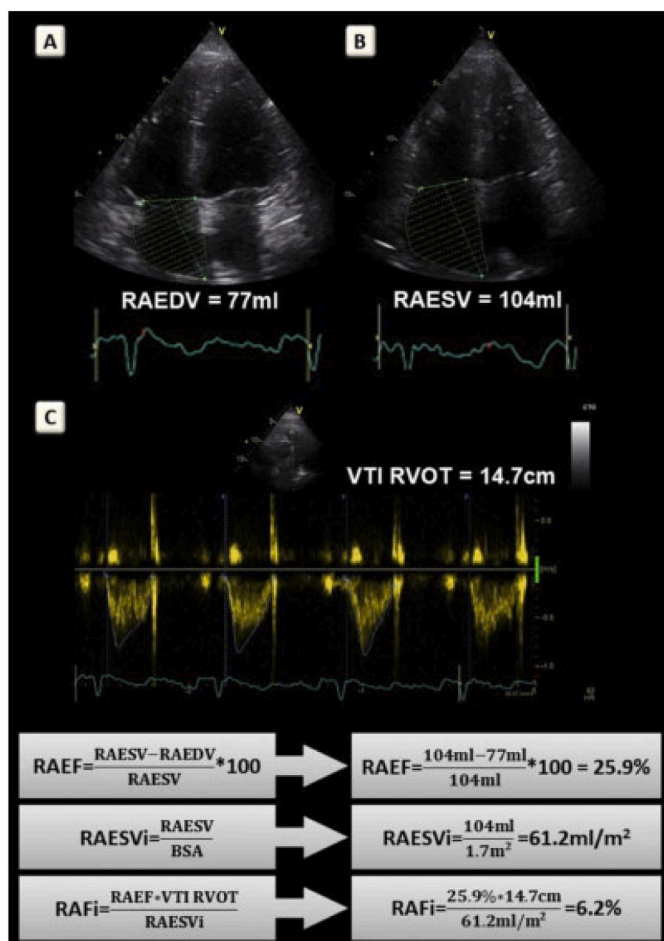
Calculation of RAFi. RAFi calculation in a 54-year-old male patient with idiopathic pulmonary arterial hypertension who was under double oral targeted therapy [45]. Right atrial volumes were calculated using the single-plane area-length method from the apical four-chamber views at end-diastole (A) and end-systole (B). The VTI-RVOT was obtained from the parasternal short-axis view (C). BSA, body surface area; RAEDV, RA end-diastolic volume; RAESV, RA end-systolic volume.
